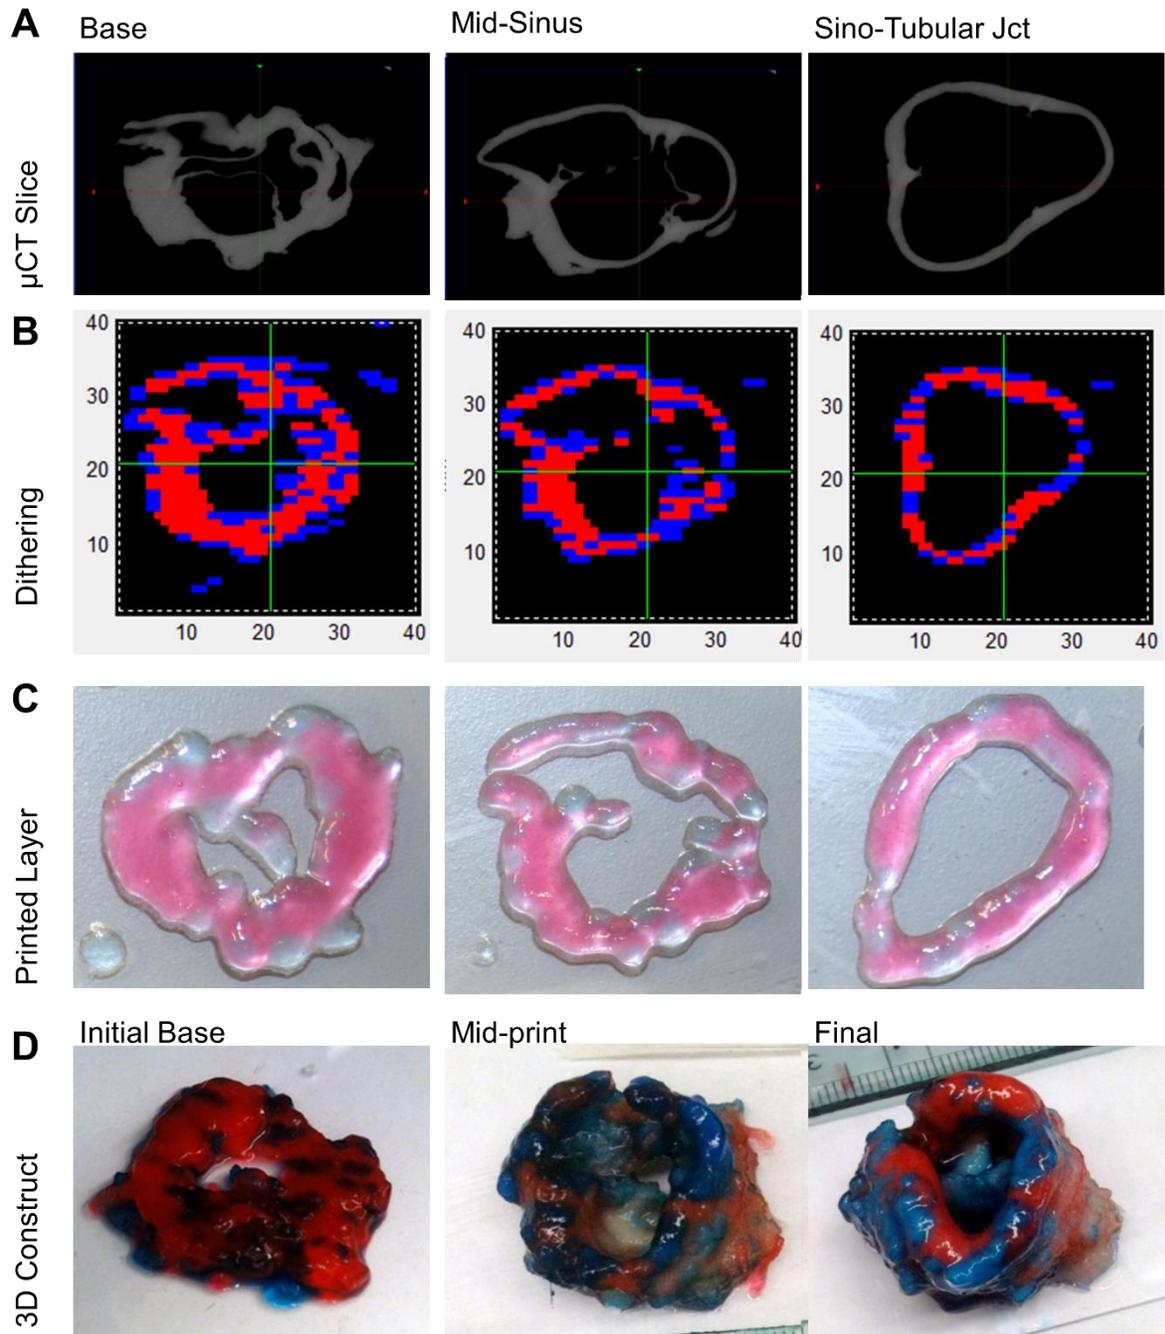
Interpretation of  $\mu$ CT and MRI intensity values for heterogeneous vector generation.
